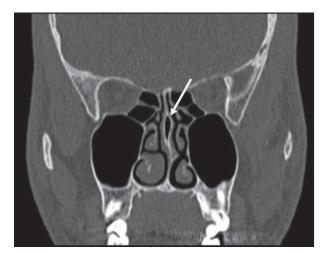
Coronal CT shows nasal septum pneumatization
